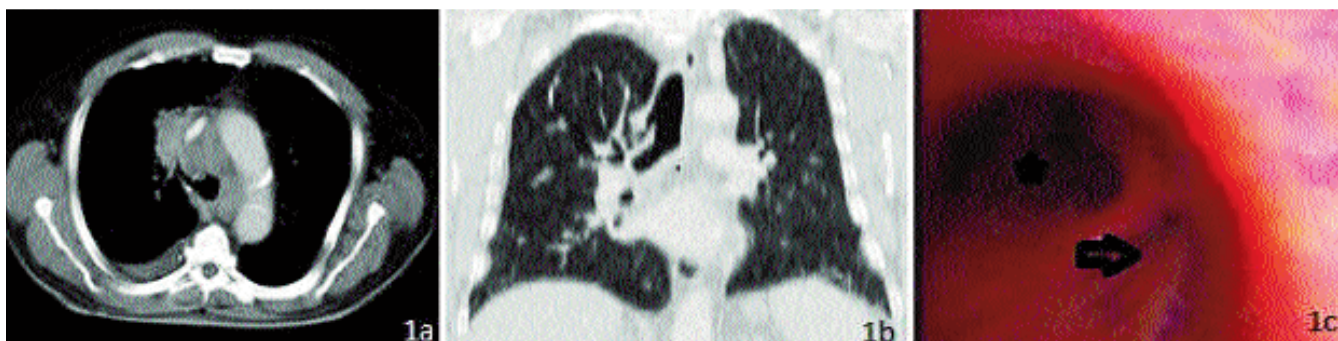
a) In Thorax CT axial mediastinum window, there are accessory bronchus originating from trachea right lateral wall and in its distal, solid mass obliterating bronchus lumen completely, spiculated irregular limited, contrasted heterogenously and lymphadenopathies, in pathological size, in mediastinum. b) In thorax CT coronal reformat parenchyma window image, main carina and right main bronchus and accessory bronchus (white arrow) leaving from the trachea, just its superior, are seen. c) In bronchoscopic examination, accessory bronchus (black arrow) leaving from the trachea right wall, about 2 cm above the main carina (star shape) is seen.
